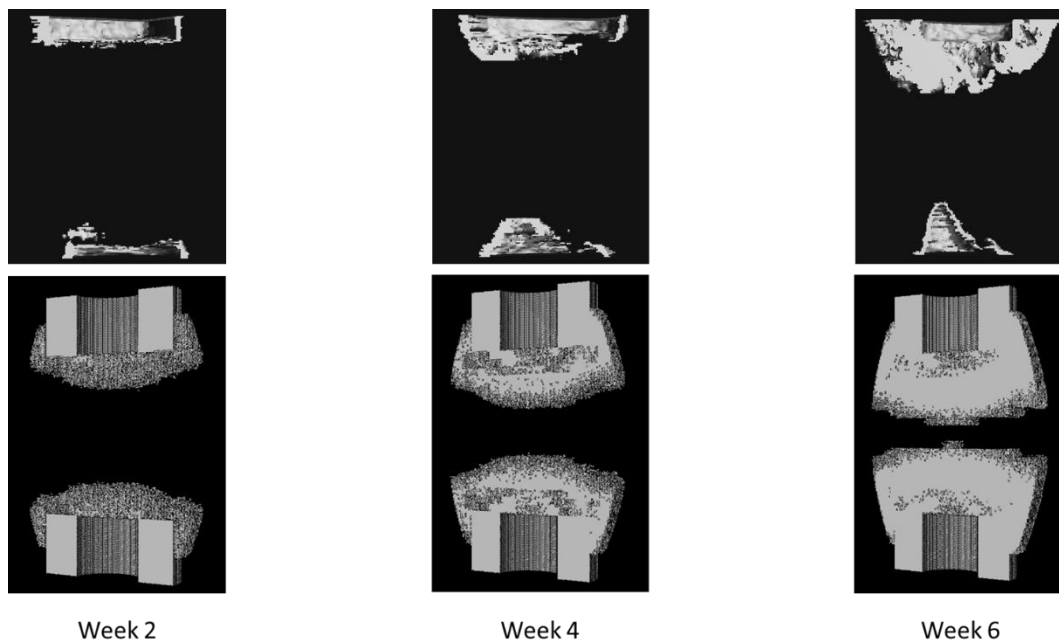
μ CT images (top) and predicted bone spatial distribution (bottom) at 2, 4 and 6 weeks post-operation under only load case conditions.
